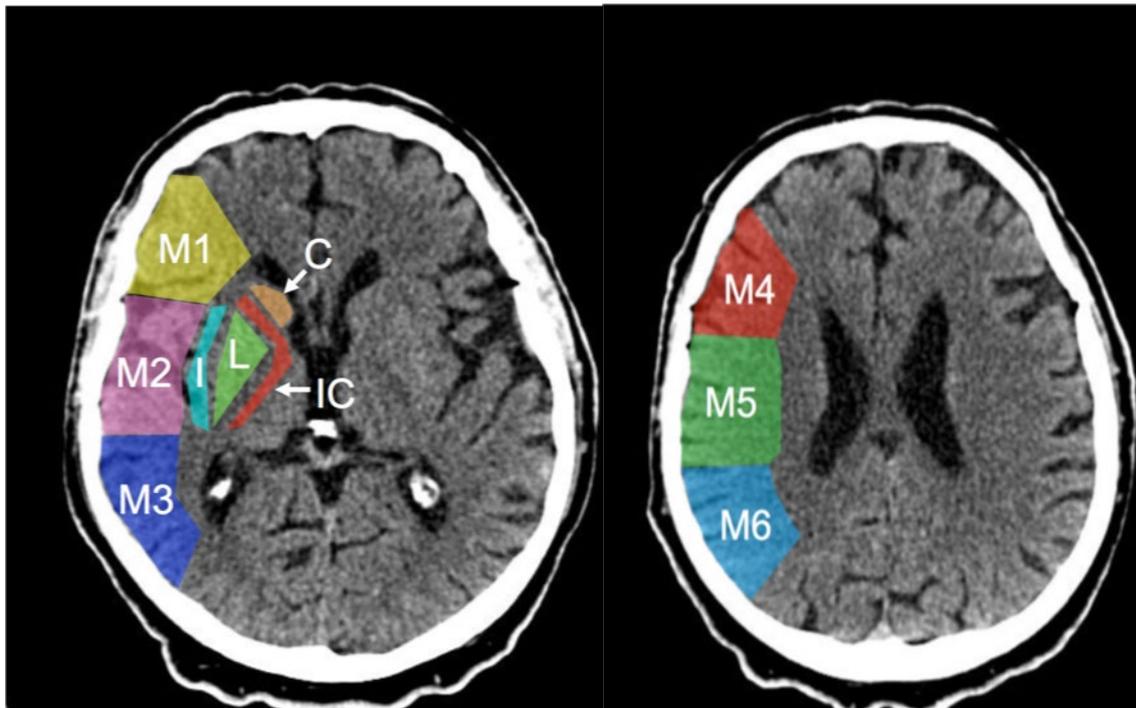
C- Head of caudate nucleus, I- Insula, IC- Internal capsule, L- Lentiform nucleus, Cortical regions (M1M6). CT representation of ASPECTS regions and 10 MCA regions. Figure from <https://radiopaedia.org/articles/albertastroke-program-early-ct-score-aspects-1>
